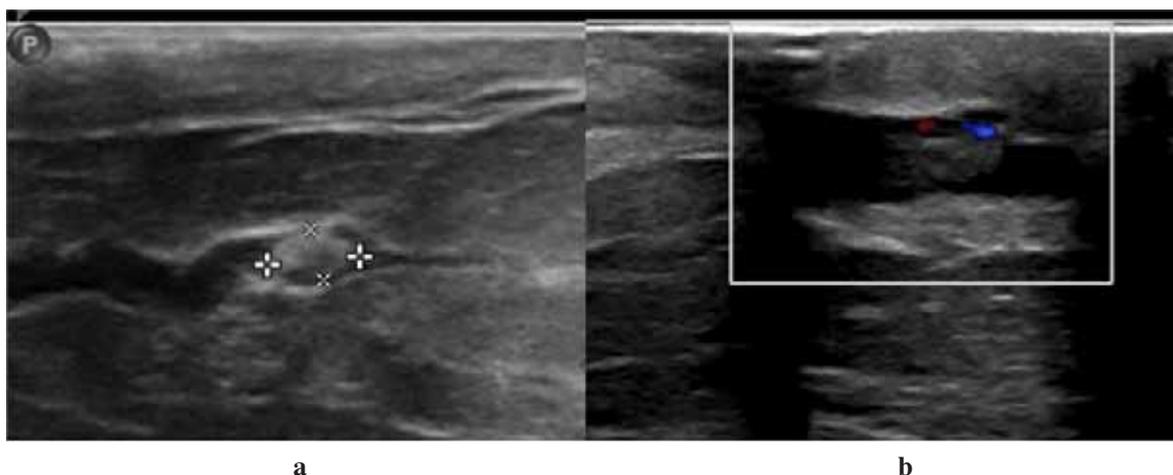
Intraductal papilloma : a. Ultrasound image shows a solid nodule in dilated duct. b. Color Doppler image reveals vascularity within the lesion.
